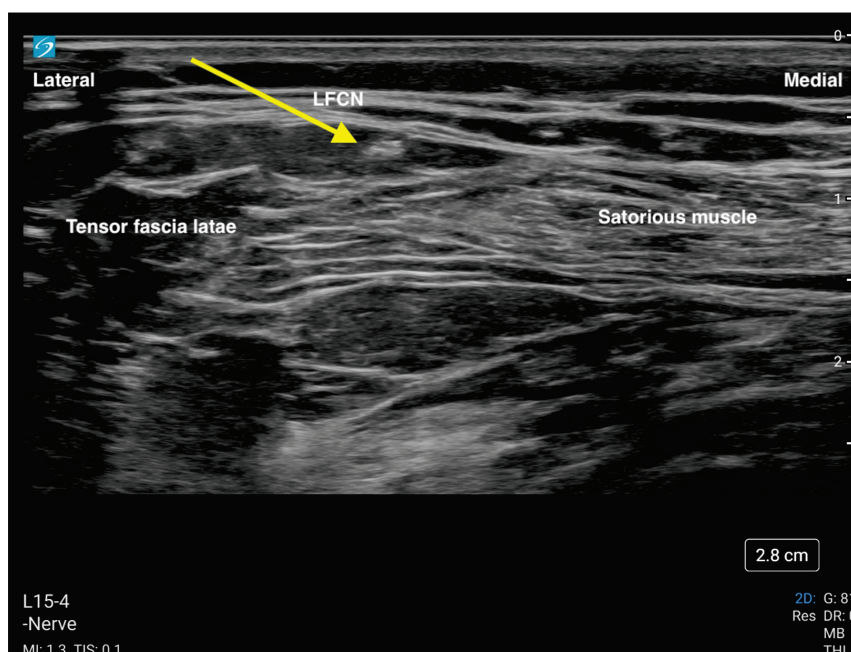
This is an ultrasound image of the lateral femoral cutaneous nerve (LFCN). The yellow arrow is pointing to the nerve. The nerve is blocked with a needle in the direction from lateral to medial.
